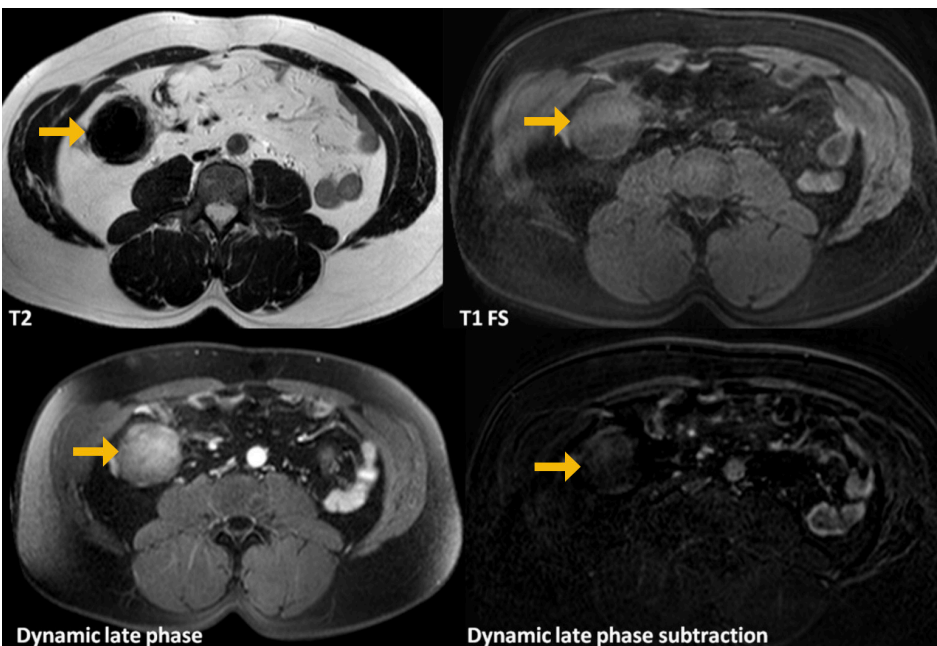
Intraabdominal fibromatosis (intermediate form) in a 57-year-old male. MR images showing a well defined intraabdominal mass (arrows) with intermediate signal on T1 weighted images, low signal on T2 weighted images and slight contrast enhancement.
